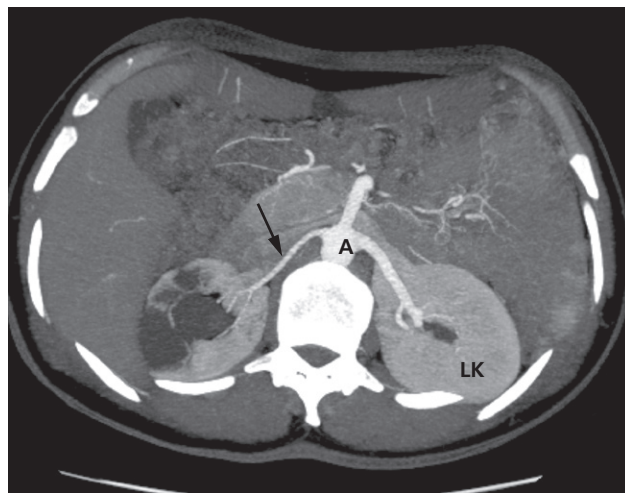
Chronic pyelonephritis secondary to stones on CT angiography. The right kidney is smaller than the left and contains multiple cystic areas following chronic infection from stone disease. The right renal artery is small in calibre (arrow). A, aorta; LK, left kidney.
